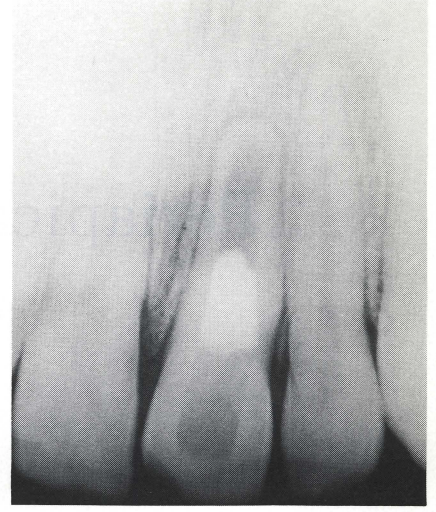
Radiograph eleven months post-apicocurettage, showing periapical healing and apical stop formation.
